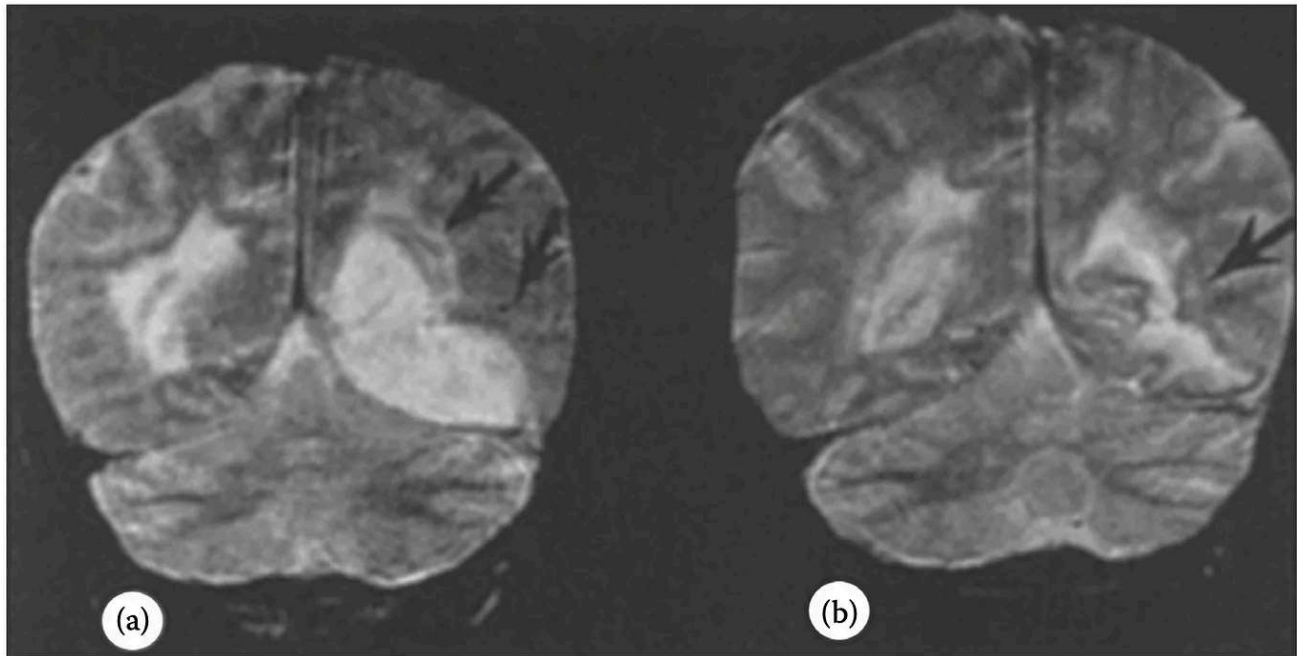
(a) T2-weighted coronal view MRI of posterior cerebral artery (PCA) territory infarct before treatment. White matter changes are seen with lateral mass effect on lateral ventricle, left thalamus involvement, and widespread edema involving the brainstem (arrows). (b) After 11 days of daily DMSO–FDP IV administration, dramatic reduction of edema and lower signal intensity are seen with an apparent improvement of gray matter and thalamic involvement (arrow). (From Karaça, M. et al., *Neurol. Res.*, 24(1), 73, 2002.)
